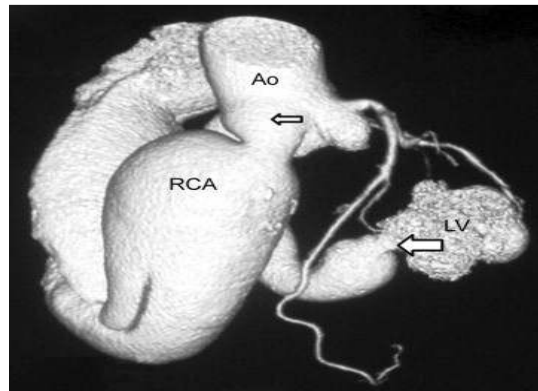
CT reconstructed coronary angiogram showing RCA to LV Fistula (arrow)
